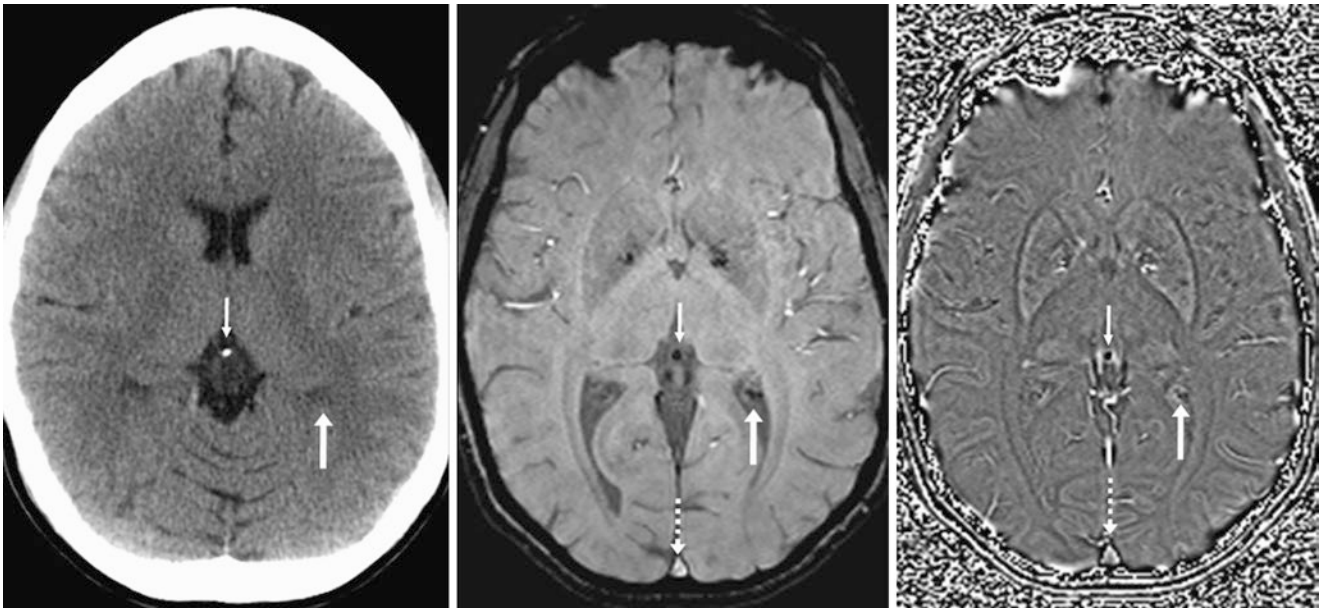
A 35-year-old patient with a NECT (*left*) had a 3 T MRI (*middle*) with accompanying phase map (*right*) of a typical location of CP (*arrows*) within the trigones of the lateral ventricles. This is probably partially calcified although not visible on NECT, since the dark signal on
